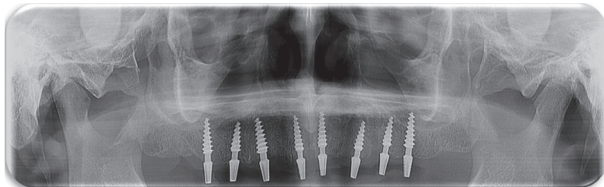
Post-operative panoramic x-ray for accurate placement.
